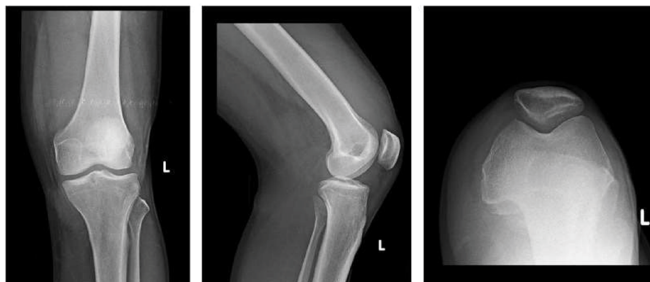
Pre-operative radiographs showing soft tissue swelling primarily in the supra- patellar region, most evident on the lateral projection (centre).
